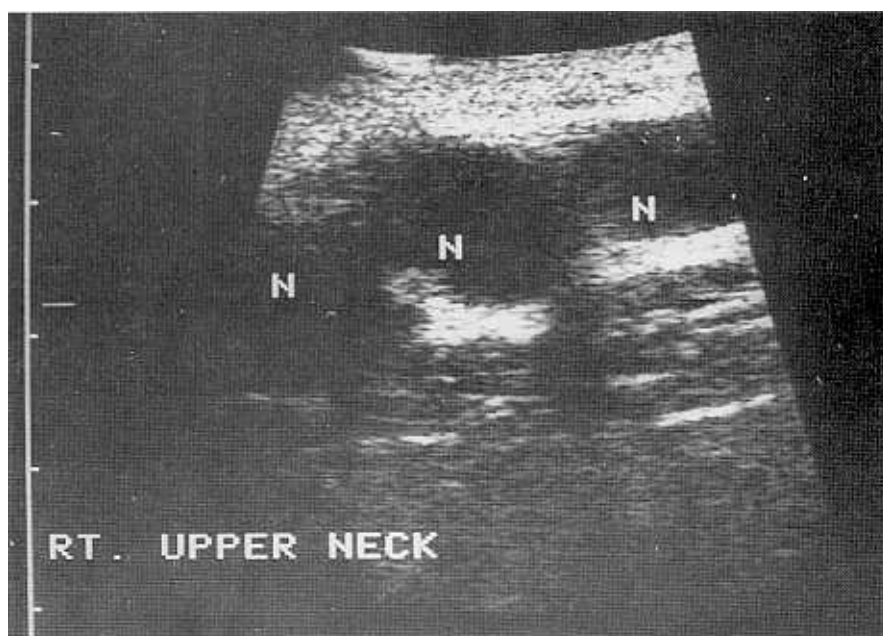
Ultrasonographic finding of conglomerated hypoechoic lymph nodes. Posterior enhancements are seen.
